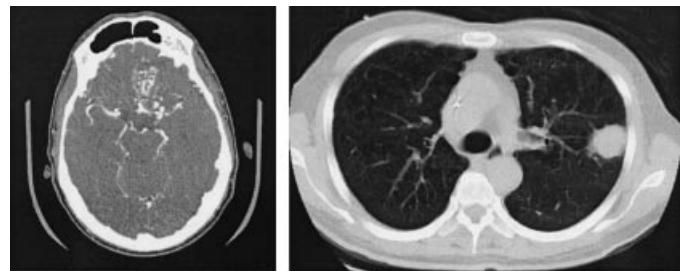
X-ray CT images collected using a GE HiLight spiral scanner (courtesy of Michael McNitt-Gray, M.D., Assistant Professor, Radiology, UCLA). The image on the left shows a cross sectional brain scan of a patient with an aneurysm; a contrast agent is used to increase the brightness of the blood vessels in the brain. The image on the right shows a chest scan with a single lesion in the right lung.
